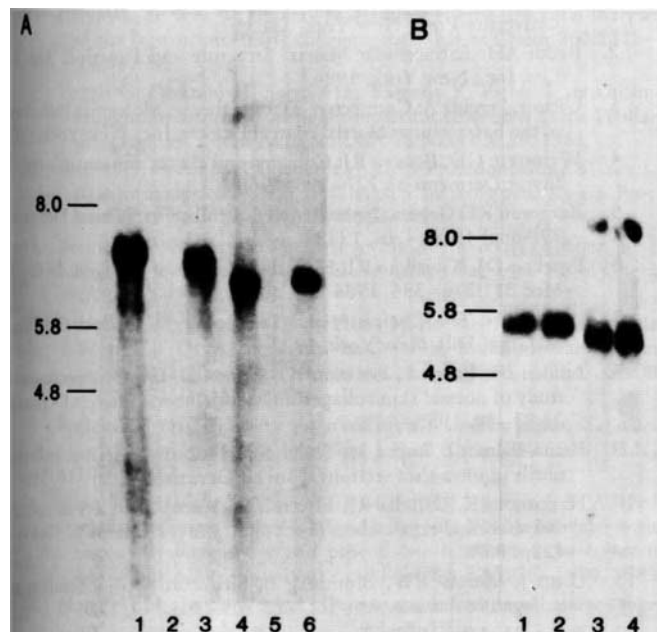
Northern transfer analysis of RNA isolated from human skin fibroblast cultures. Poly(A)⁺ RNA was isolated and electrophoresed on a 1% agarose gel. The RNAs, 1 μ g per lane, were transferred to nitrocellulose filters and hybridized with type IV procollagen cDNAs (*panel A*) or laminin B1 and B2 chain cDNAs (*panel B*). *Panel A*: Hybridizations with α 1(IV) (*lanes 1-3*) α 2(IV) (*lanes 4-6*) chain cDNAs. *Lanes 2* and *5* contain RNA from a 33-year old male, while *lanes 3* and *6* contain RNA from cultures isolated from a 14-week old fetus. For comparison, in *lanes 1* and *4*, RNA from fibroblast cultures established from a newborn male with perinatally lethal osteogenesis imperfecta is shown; this cell line has been previously shown to synthesize large quantities of type IV procollagen. *Panel B*: Hybridizations with human laminin B1 (*lanes 1* and *2*) or B2 (*lanes 3* and *4*) chain cDNAs. *Lanes 1* and *3* contain RNA from adult skin fibroblast cultures and *lanes 2* and *4* contain RNA from fetal cell cultures, as indicated in *Panel A*. The 5.8 and 4.8 kb markers indicate the migration positions of polymorphic transcripts of human pro- α 1(I) collagen chain mRNA, while the 8.0 kb marker indicates the position of fibronectin mRNA, as determined by parallel hybridizations of RNA blots from the same electrophoretic runs. The mRNAs in *lanes 2* and *5* of *Panel A* are not readily visible with this exposure; however, upon extended exposure to x-ray films, the bands are evident. These observations are consistent with differential regulation of basement membrane components, type IV collagen and laminin, during chronologic aging. (From Ref 186, with permission.)
